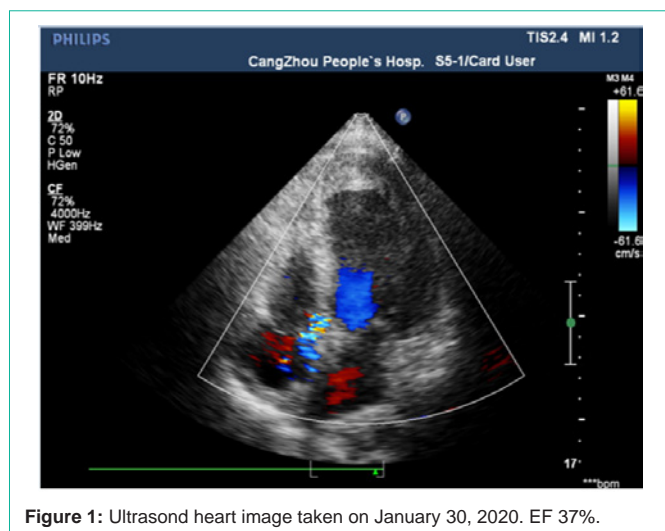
Ultrasound heart image taken on January 30, 2020. EF 37%.
